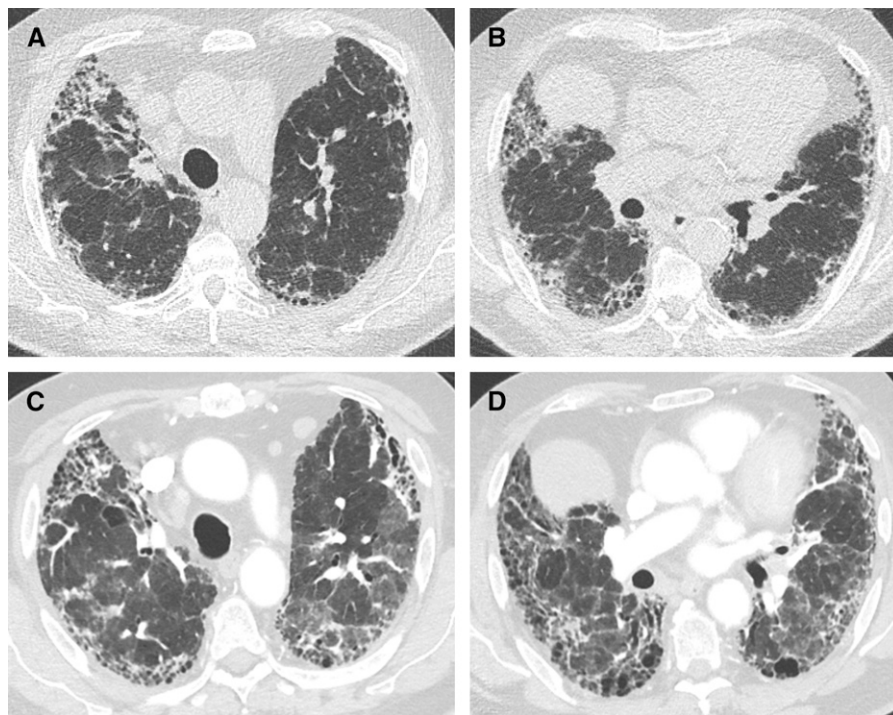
Acute exacerbation of idiopathic pulmonary fibrosis. (A and B) Transverse computed tomography sections obtained in the upper and mid lung zones and (C and D) during acute exacerbation showing newly developed, bilateral ground-glass opacification in both lungs on a background of usual interstitial pneumonia pattern.
